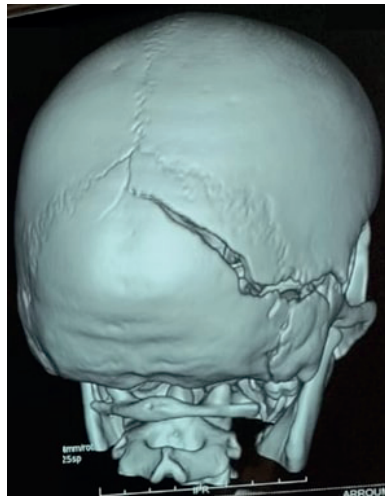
Three-dimensional-computed tomography scan reconstruction of skull showing a right linear occipitotemporal fracture.
